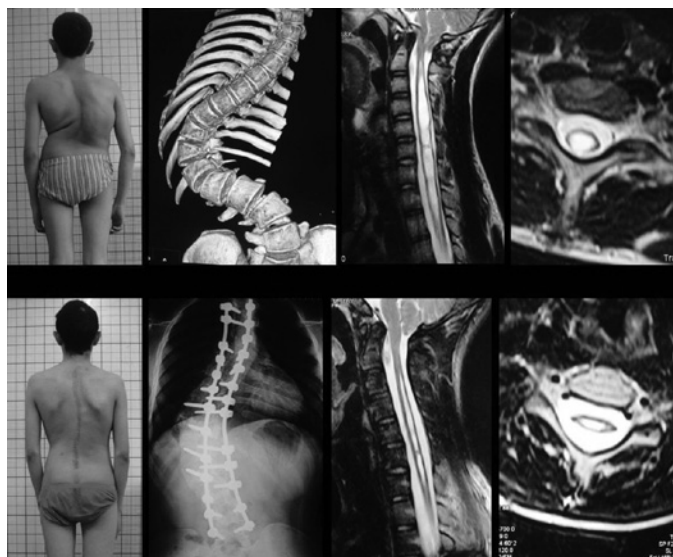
The clinical feature and radiograph of the patient, and several contiguous wedge shape vertebrae around T11 apical region could be noticed. Following PVCr, the coronal and sagittal alignments were recovered with fine trunk balance. Syrinx shrinkage was confirmed during postoperative follow-up.
